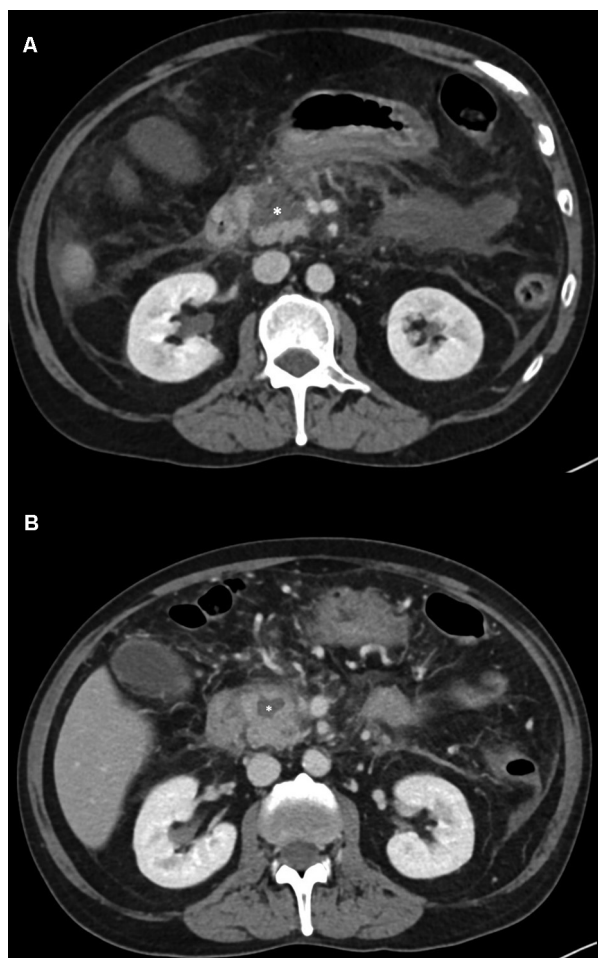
Computed tomography (CT) showing pancreatic regeneration in alcohol-related necrotizing pancreatitis. (A) Contrast-enhanced CT (CECT) in axial plane shows a lack of enhancement in a segment of the pancreatic head (white star), consistent with pancreatic necrosis. (B) Follow up CECT done after a few weeks in the same patient shows an increase in areas of parenchymal enhancement and reduction of necrotic area (white star). This is due to parenchymal regeneration.
